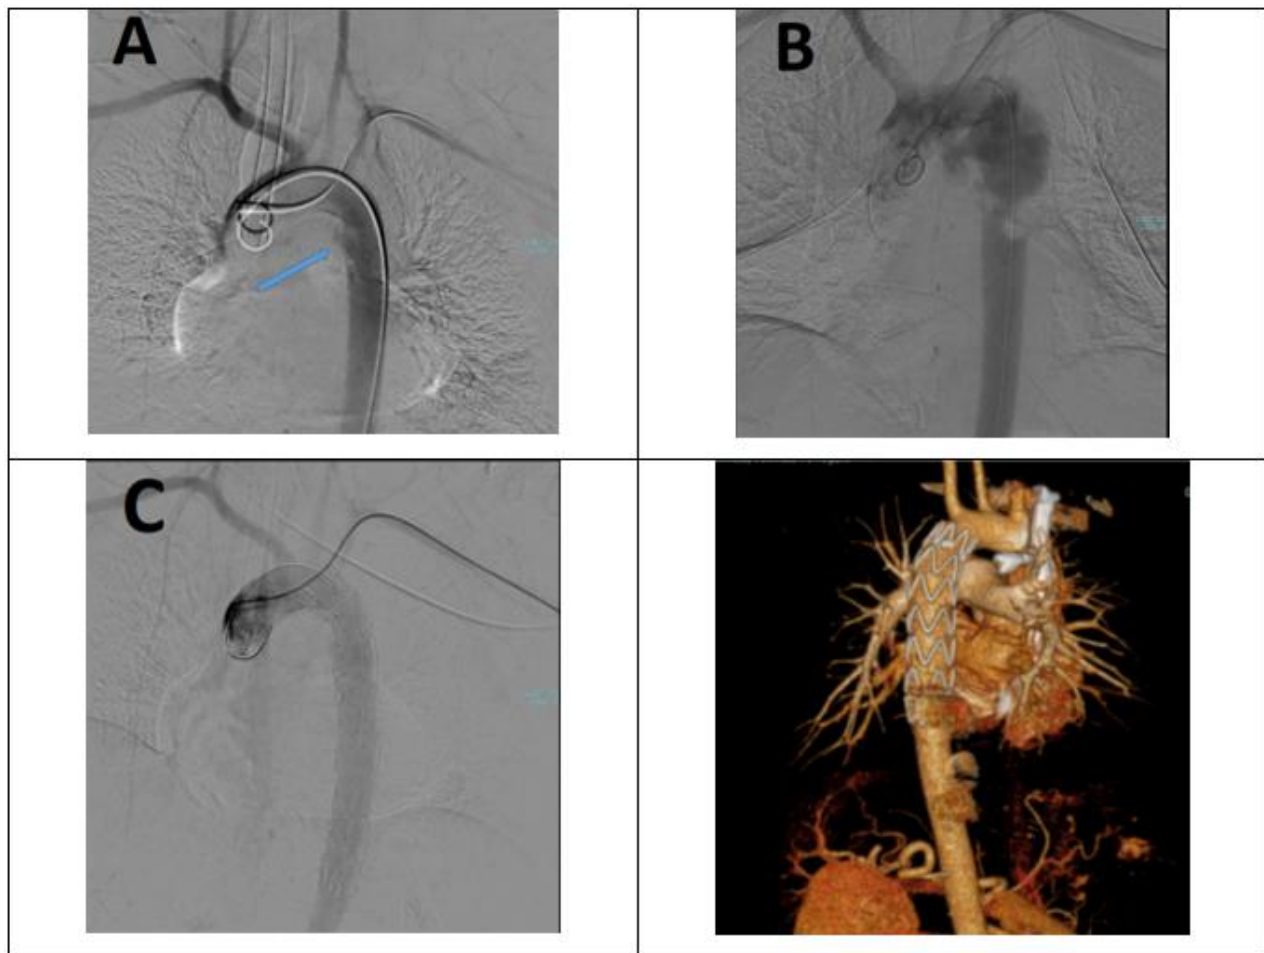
1a. Grade III injury, 1b. Grade IV injury, 1c. Stent graft deployment, 1d. Follow-up CT-angiogram
